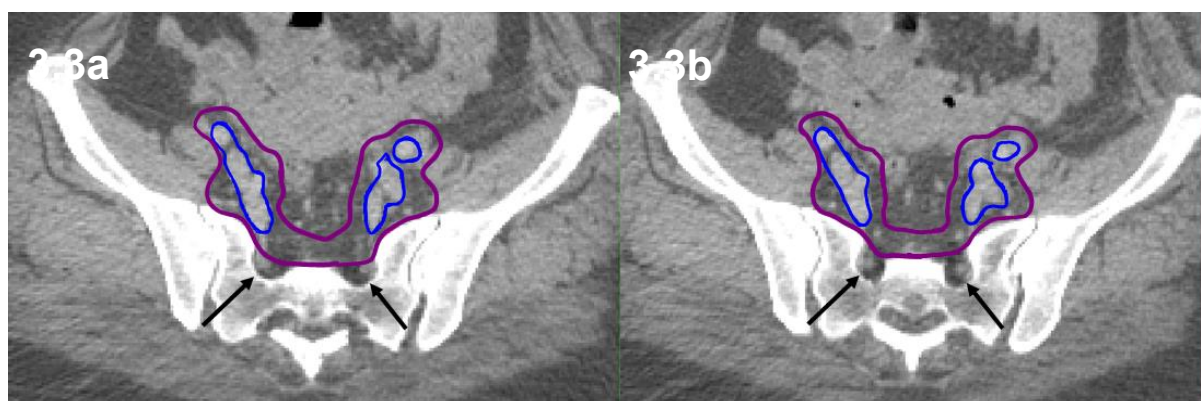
Transverse CT with CTV2 outlined not including the sacral foramina (arrowed).
